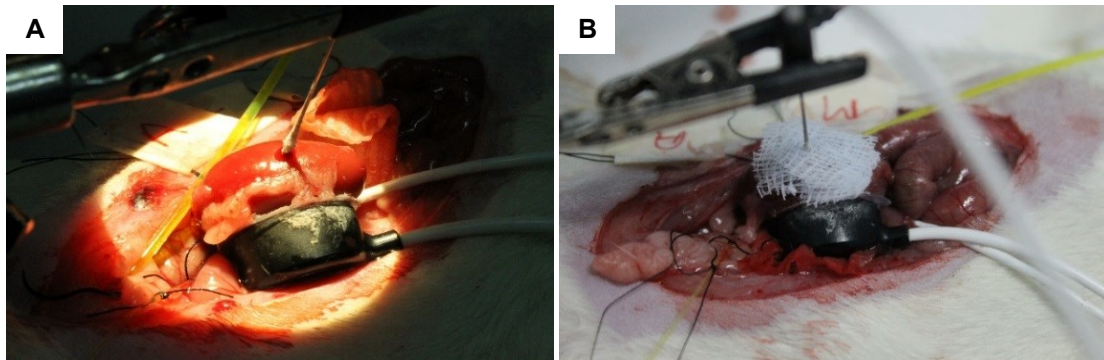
Placement of laser Doppler probes to measure intrarenal flux
